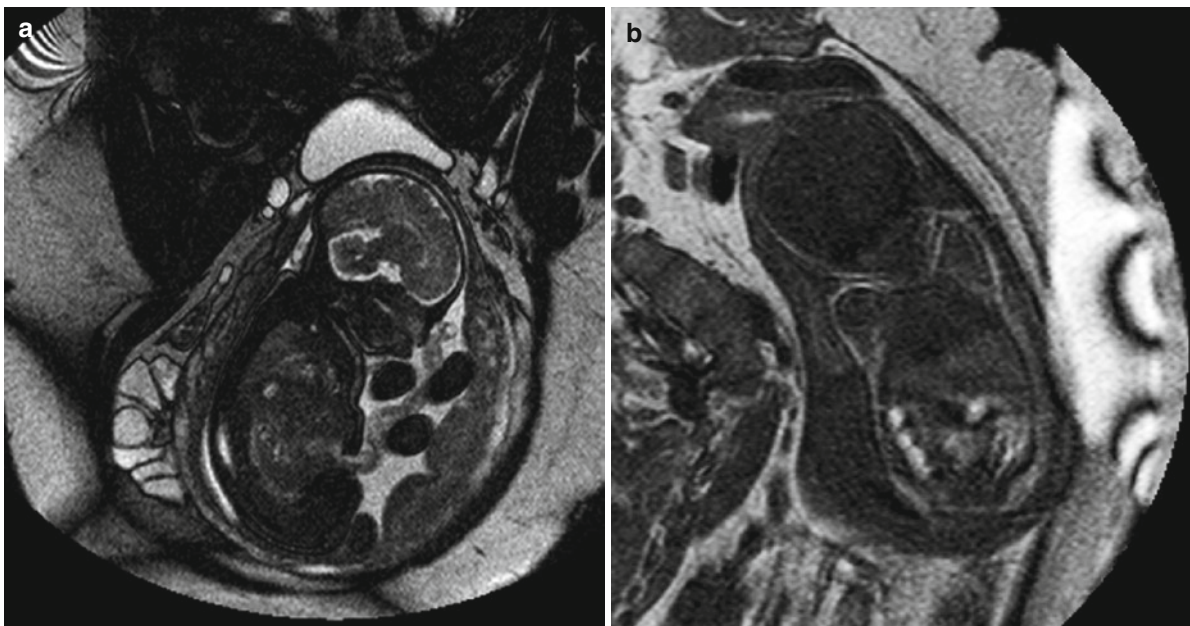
Mother with high BMI at GW 35+5. Despite the reduced image quality, fetal structures can be evaluated sufficiently. (a) Sagittal T2-weighted image. (b) Coronal T1-weighted image with a fold-over artifact (*right lateral border* of the figure)
